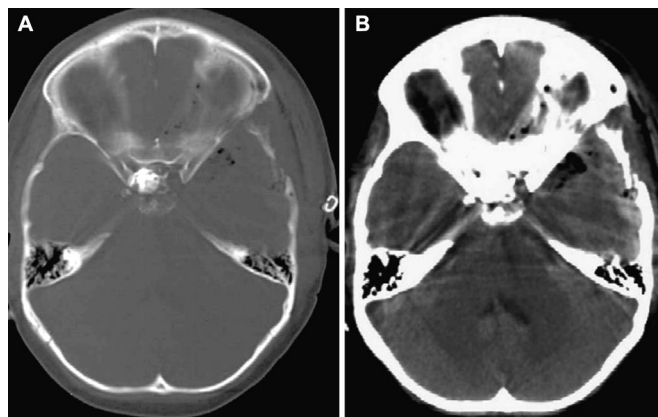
Axial CT scans in bone (A) and the parenchymal (B) window demonstrating the NBCA over the clinoid process and the calcified mass. Compare with Figure 1C.
